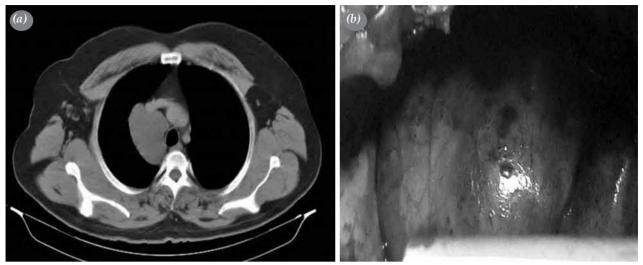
A 43-year-old man presenting with cough and mediastinal cystic lesion. (a) thoracic computed tomography showing the extent of the mass, (b) the intraoperative view of the mass lesion filled with fluid.
